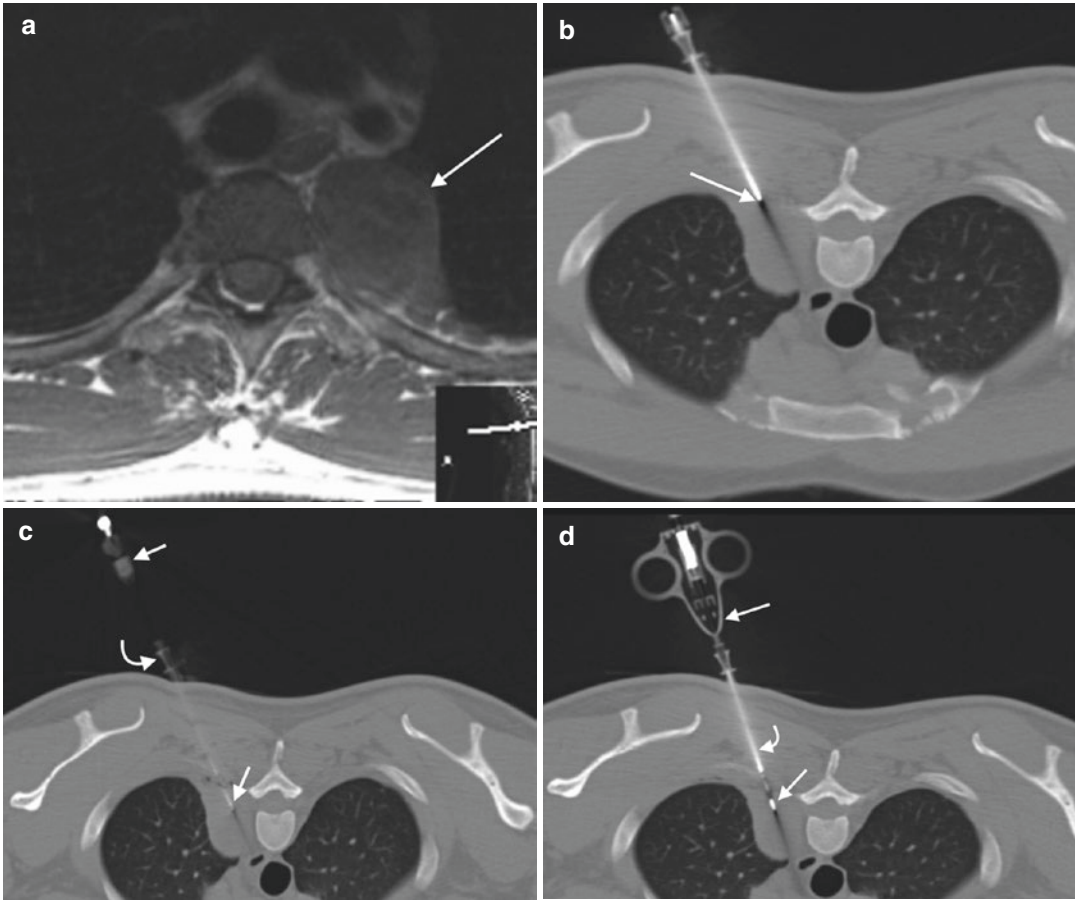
A 30-year-old male with incidental mass seen on chest radiograph. T1-weighted axial image (a) shows solid intermediate signal intensity soft tissue mass (*arrow*) adjacent to the upper thoracic spine. Axial CT image (b) shows placement of a guide needle with advancement of the needle tip to the margin of the lesion (*arrow*); the needle is purposely angled away from the lung. Axial CT image (c) shows coaxial insertion of a 22 gauge Chiba
